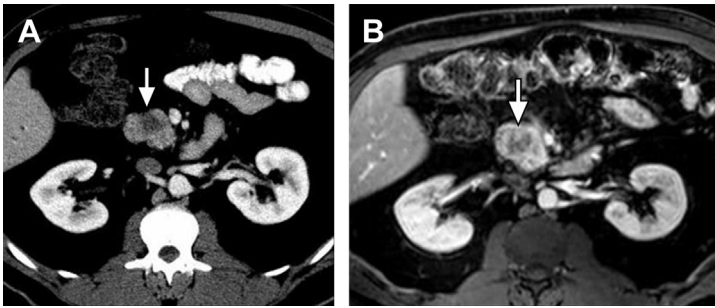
Pancreatic head mass on multidetector computed tomography (MDCT) and MRI. (A) Axial contrast-enhanced MDCT and (B) T1-weighted gradient echo with fat suppression images through the pancreatic head demonstrate a focal mass (arrow) completely surrounded by pancreatic parenchyma with no extension beyond the contour of the pancreas suggesting a resectable tumor. Both imaging modalities have comparable accuracy for staging pancreatic adenocarcinoma.
